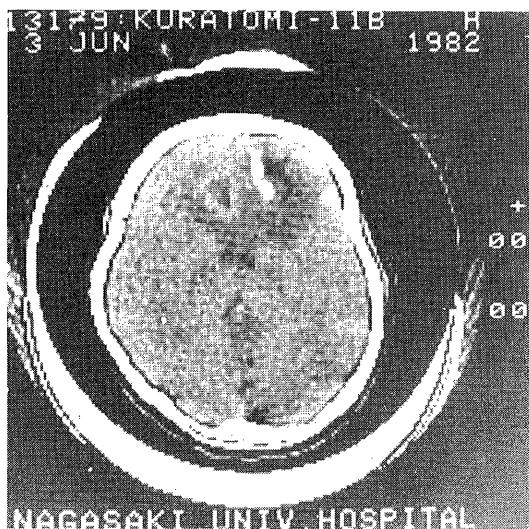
A plain CT scan of brain shows irregular outline of low density area with calcification in right frontal lobe.
